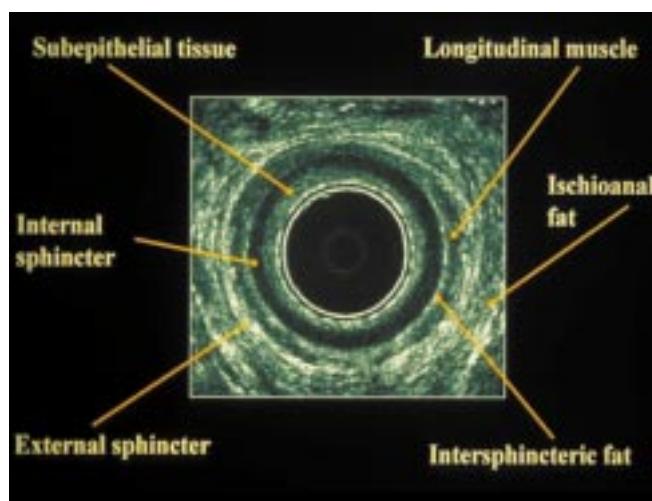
Normal anal ultrasound
